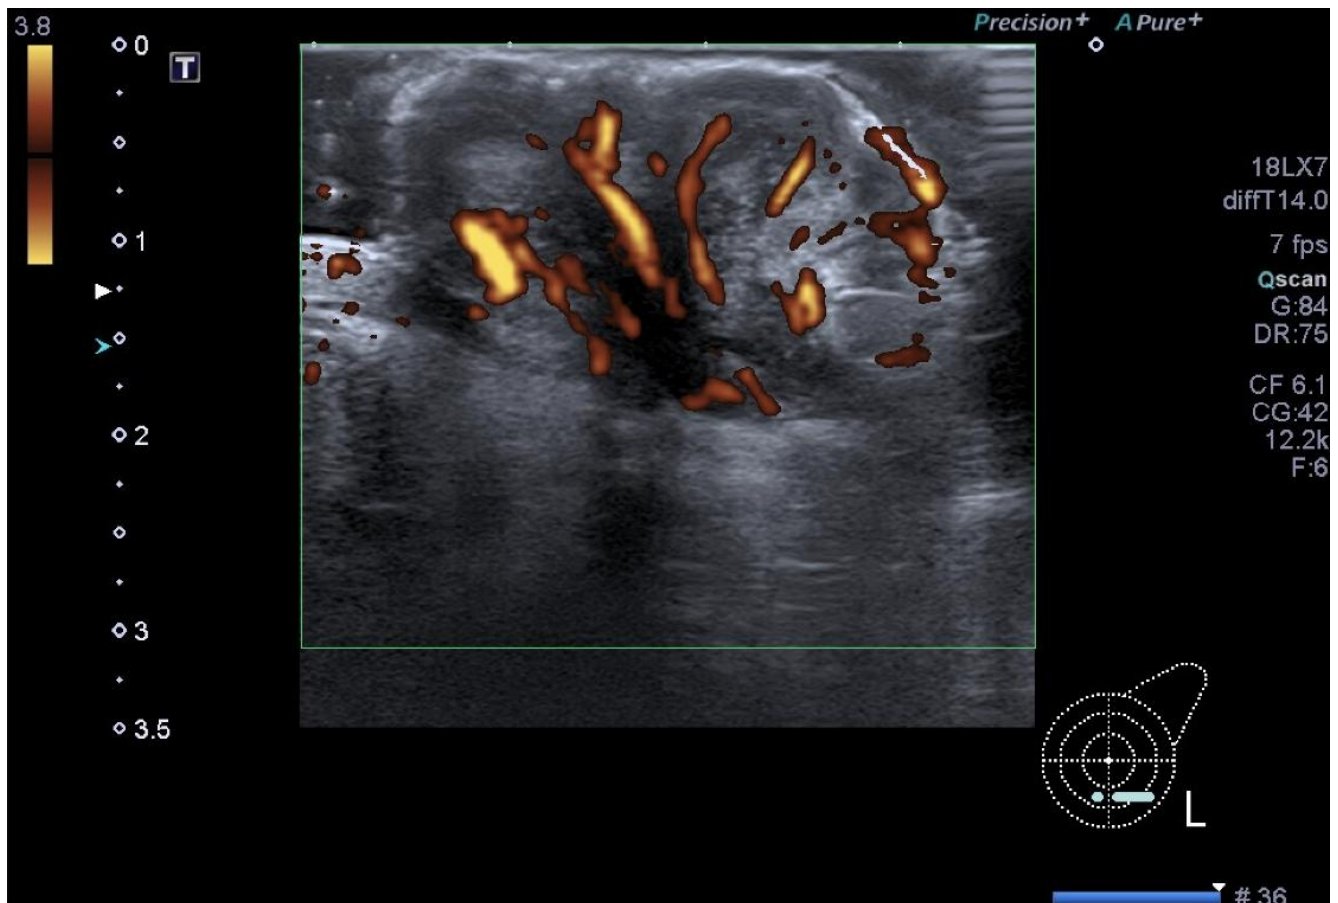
Doppler Ultrasound of the Left Breast. The image reveals a superficial, exophytic mass in the lower outer quadrant, exhibiting heterogeneous echotexture with prominent internal vascularity.
